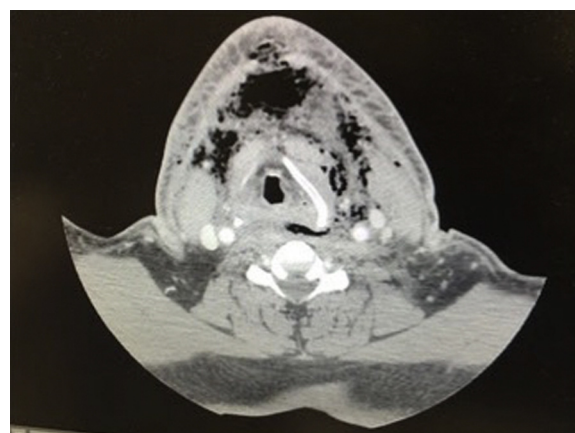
CT showing presence of gas in the anterior cervical space.
